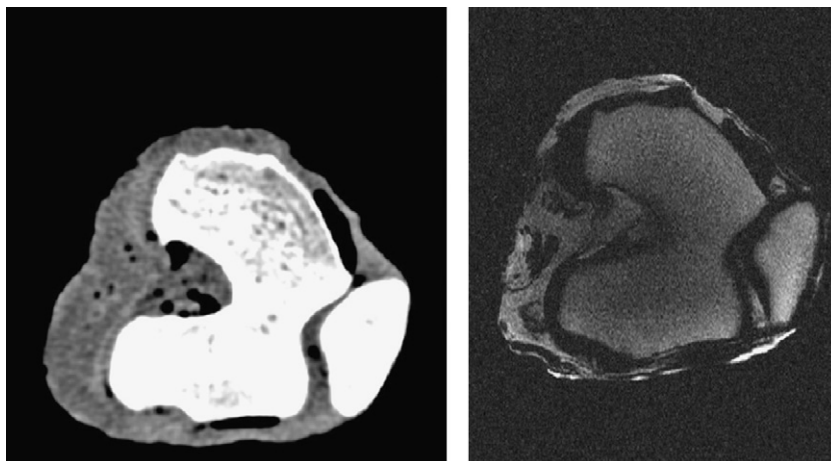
CT (left) and MRI (right) axial images of one exemplary knee. A clear differentiation between the tissues is possible in both scan procedures.
